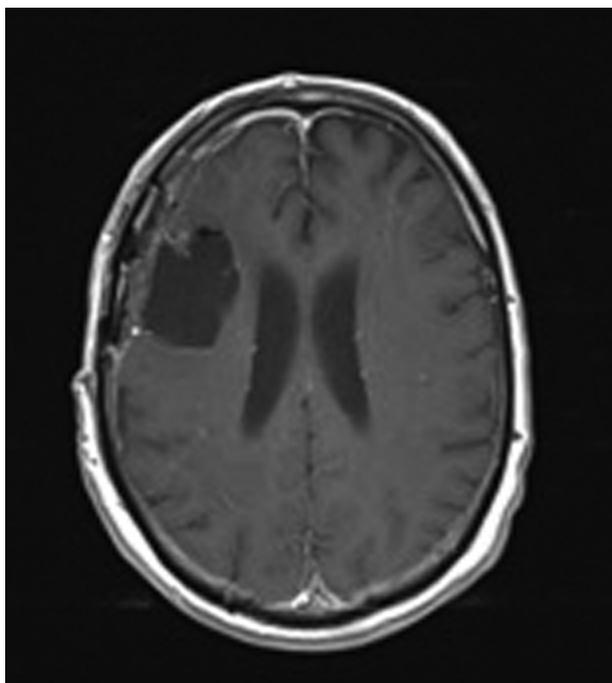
T1 axial postoperative magnetic resonance imaging with contrast confirmed total removal of the lesion.
